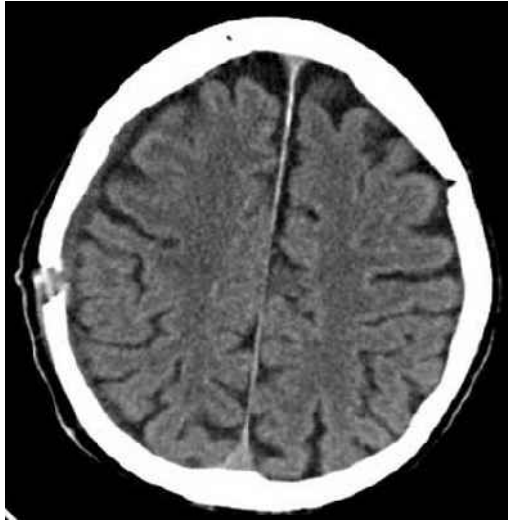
Axial CT image of the brain at one month postoperation shows the burr hole clearly.
